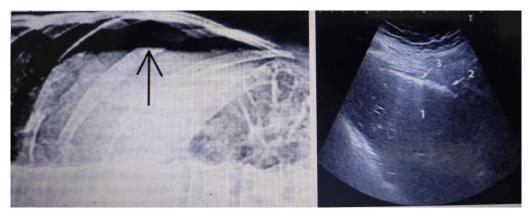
On the left side of the image, X-ray detection of free gas in the right subdiaphragmatic zone with the patient lying on his left side. On the right side of the image, the echogram shows free gas in the form of a hyperechoic line (3) with a dorsal track (1).
